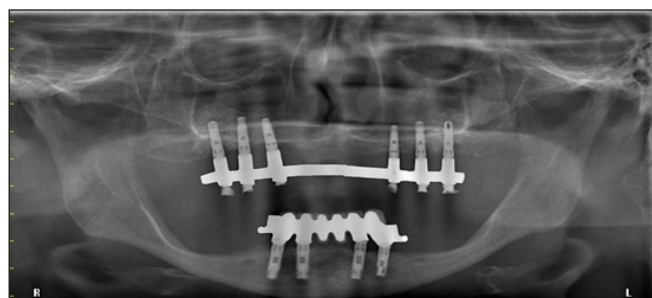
The final prosthetic reconstruction. Panoramic radiograph of the implant supported overdenture.
